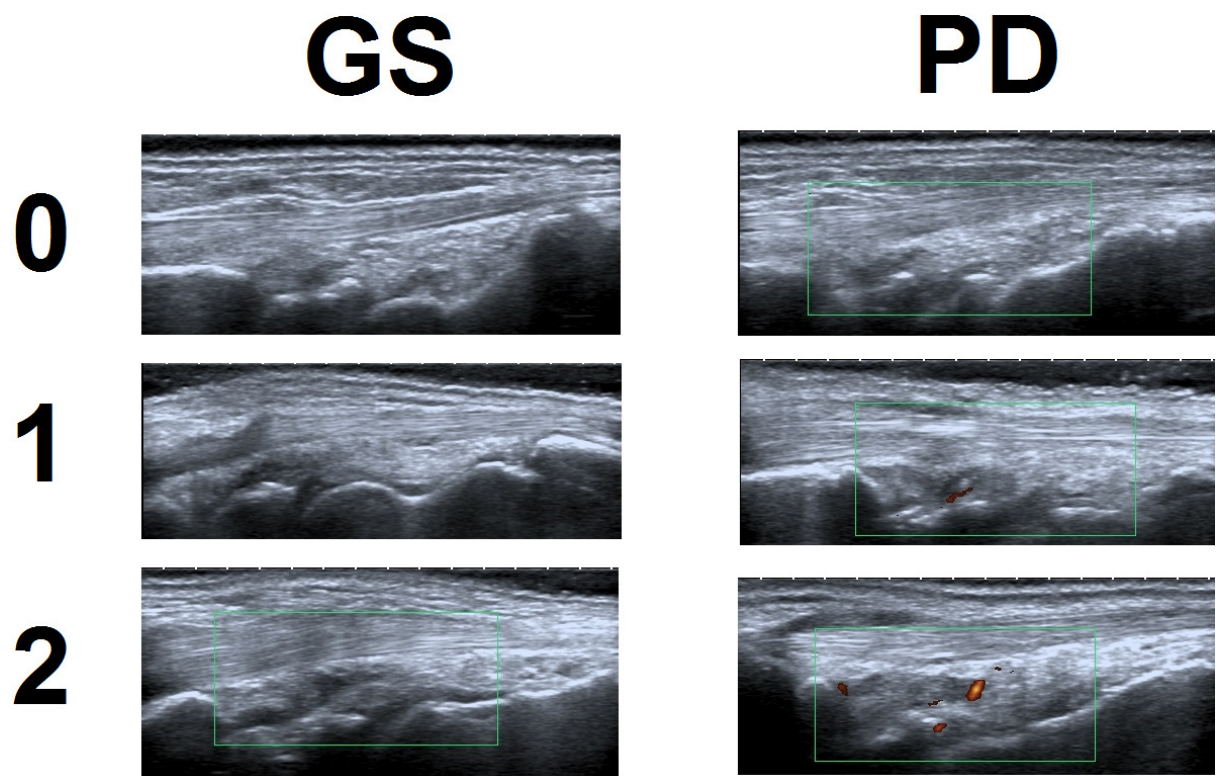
Representative ultrasound images from the BioRRA study demonstrating semi-quantitative scoring of greyscale (GS) and power Doppler (PD) at the dorsal view of the wrist, as agreed by both ultrasound assessors. No instances of grade 3 GS or PD at the dorsal view of the wrist were recorded.
